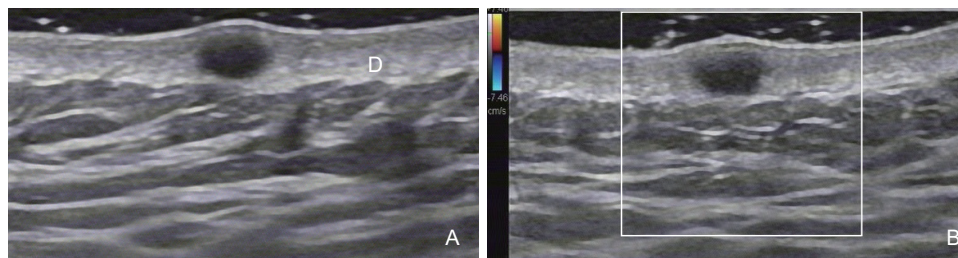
A dermatofibroma in the dermis. (A) Grayscale sonography showed a 5×3mm well-circumscribed hypoechoic lesion located at dermis (D); (B) Color Doppler imagine showed no blood flow signals within or around the tumor.
